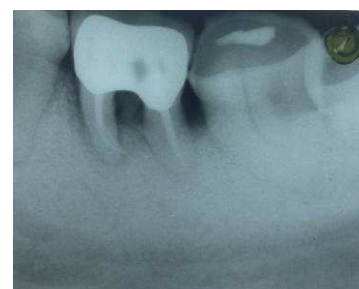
Intraoral periapical radiograph of 44 tunnelled crown after 6 months
